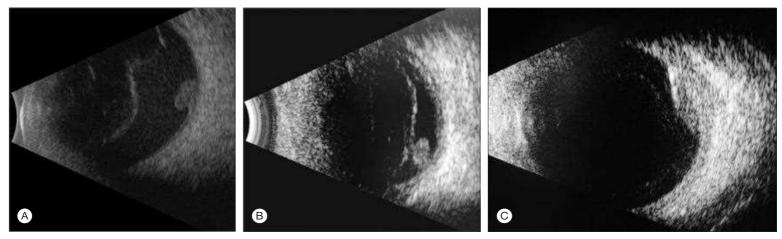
B-scan ultrasonography images depicting the mushroom-like configuration of Candida (A) and Aspergillus (B) endogenous lesions compared with the subretinal abscess of Klebsiella (C).
